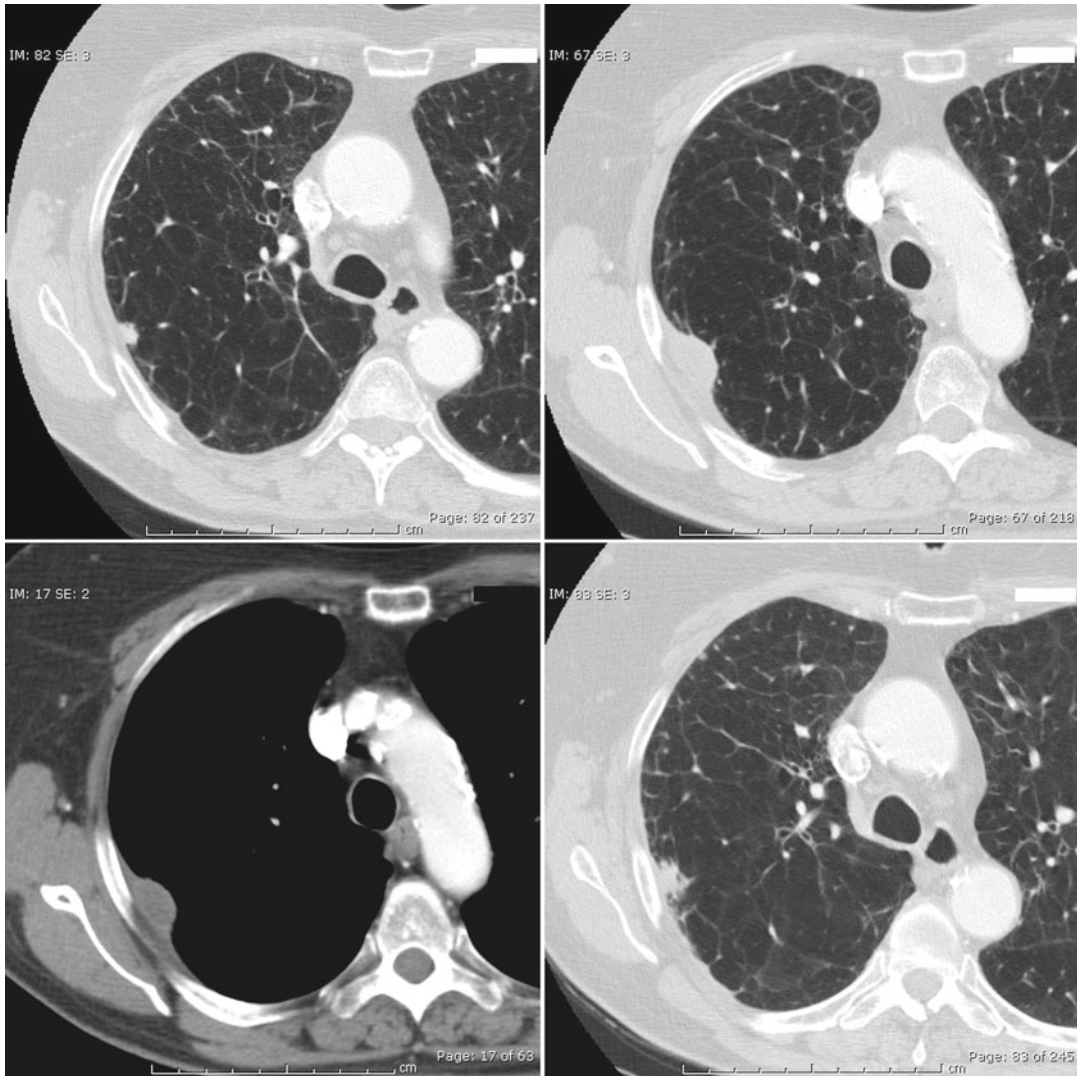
Evolution of post-RFA CT findings. A diagnostic CT scan made before biopsy and RFA reveals a small peripheral lesion in the upper lobe of the right lung (*upper left*). This was found to be a NSCLC and was treated with RFA. Three months later, a contrast-enhanced CT shows a larger, well-defined opacity at the site of RFA
